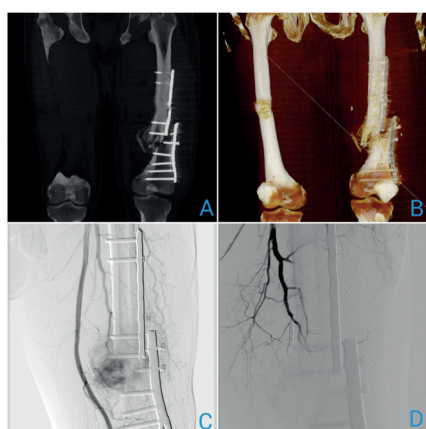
Computed tomography — pathological fracture and a broken stabilizing plate; A. 3D multiplanar reconstruction; B. 3D volumetric reconstruction. Digital subtraction arteriography; C. Metastatic tumour. Vascular supply from the deep femoral artery; D. Shadow of the embolization coil and effective occlusion of the tumour blood supply. Absence of flow in the distal segment of the deep femoral artery
